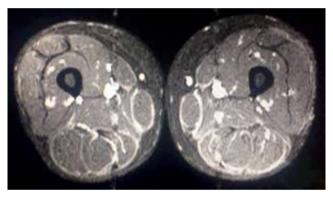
MRI of the lower limbs, axial view Thickening of fascia in medial and posterior areas of the lower limbs
